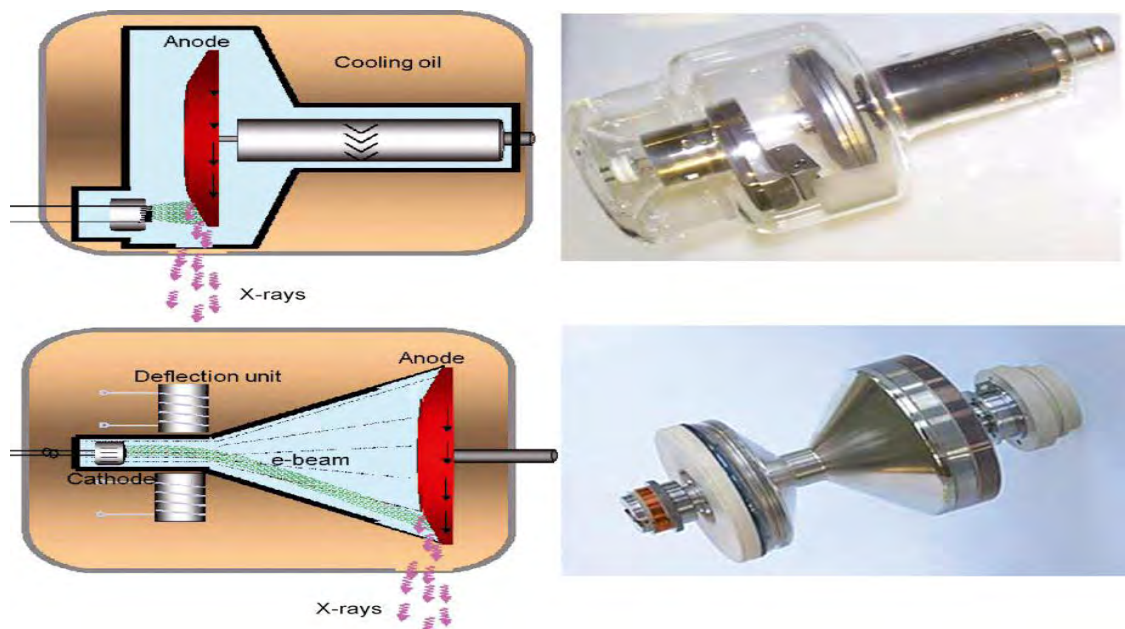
Conventional X-ray tube
